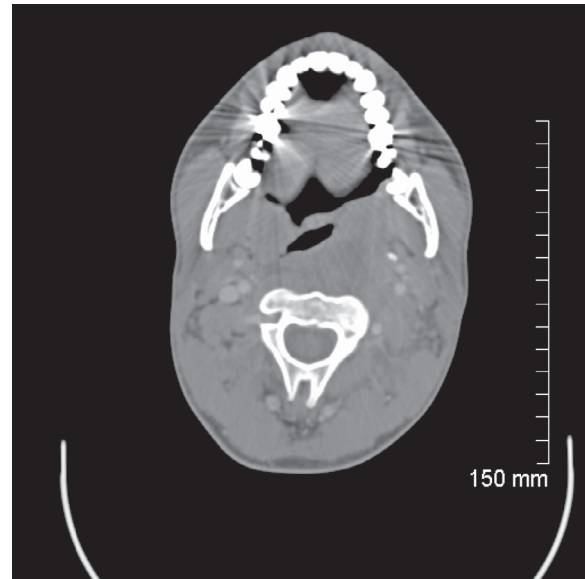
CT scan showing a left-sided parapharyngeal abscess.
